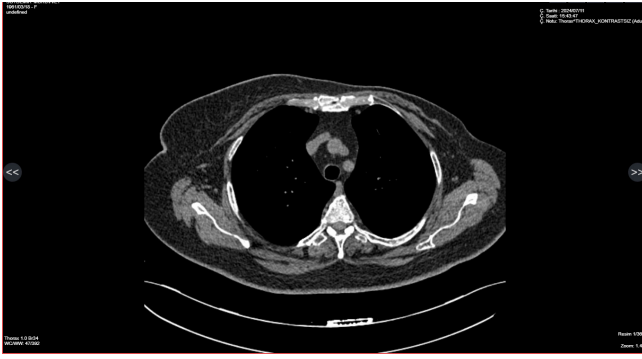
Thorax computed tomography after treatment
